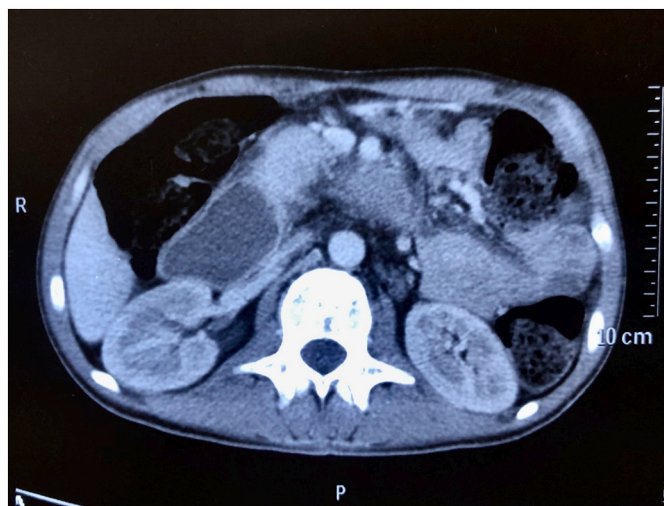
Pre-chemotherapy CT scan of the patient shows distended stomach and dilated pylorus due to distal obstruction in the duodenum.
